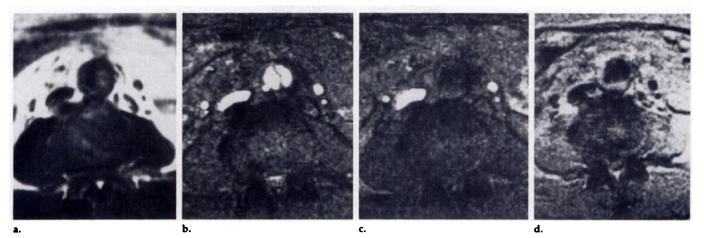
MR images obtained in a 64-year-old male patient with type B thoracic aortic dissection. (a) SE image (400/15, 256×192 matrix, 40×40 -cm field of view, 5-mm section thickness) with parallel presaturation suggests a thrombosed false lumen on the left side. (b) Axial GRE image (25/8, 30° flip angle, 5-mm section thickness, 256×256 matrix, and 40×40 -cm field of view) clearly shows patency of false lumen and ulceration on right posterior wall of aorta. Plaque along the aortic wall appears dark. (c) Parallel presaturation in same section as b fails to create a uniform flow void. (d) Selective preinversion turboFISP image (256×256 matrix, 44×44 -cm field of view, 1,800-msec TR, 475-msec TI) similarly shows true and false lumina; plaque along the aortic wall appears bright.
